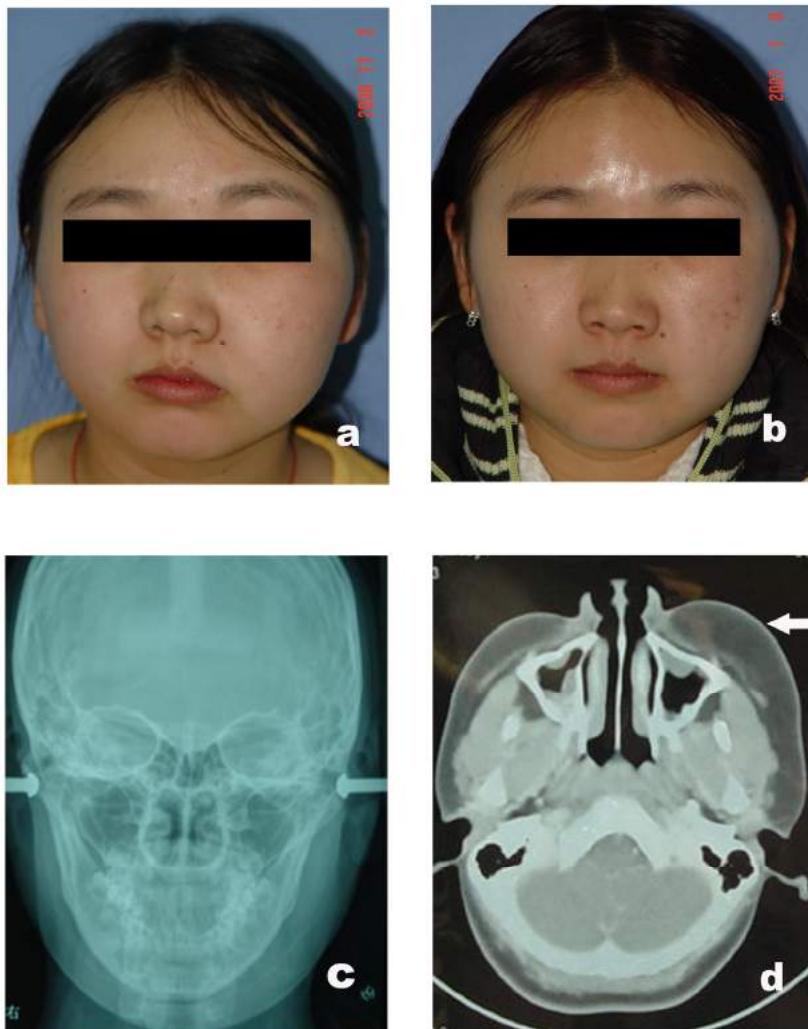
a. The facial contour is asymmetric due to the congenital localized adiposis in the left face. Note that the left corner of the mouth is moved down. b. At 2 months after laser lipolysis, the enlarged adipose tissue has been removed; the asymmetry is significantly improved; and the corners of the mouth are symmetric. c. Anteroposterior x-ray of the skull before the operation. The bilateral maxilla and mandible are symmetric (arrows), whereas the soft tissues of the left face (asterisk) are obviously thicker than those of the right side. d. Magnetic resonance imaging (MRI) indicates the enlarged soft tissue on the left side of the face (asterisk), which basically consists of adipose tissue
